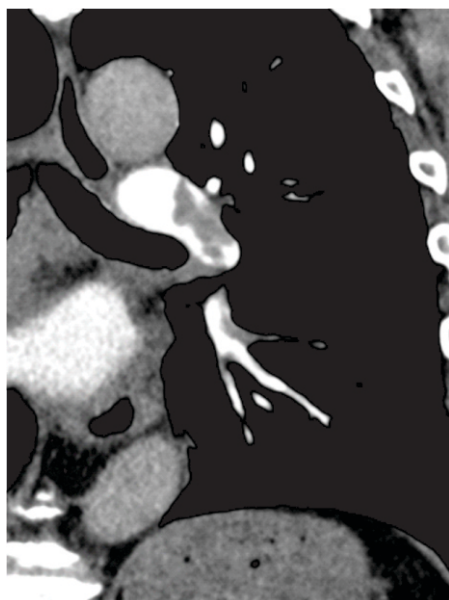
CT Pulmonary Angiogram of a Confirmed Case of COVID-19 showing Pulmonary Artery Filling Defects of Emboli.
